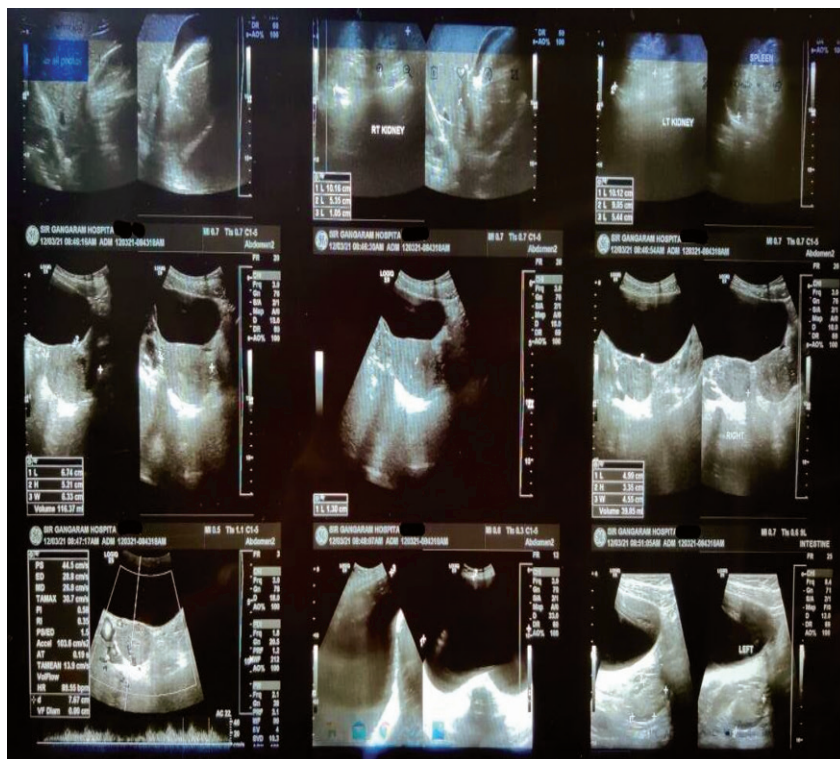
Ultrasound of abdomen and pelvis revealing a large cystic lesion of approx. volume 665 ml extending from the epigastrium to the pelvis
